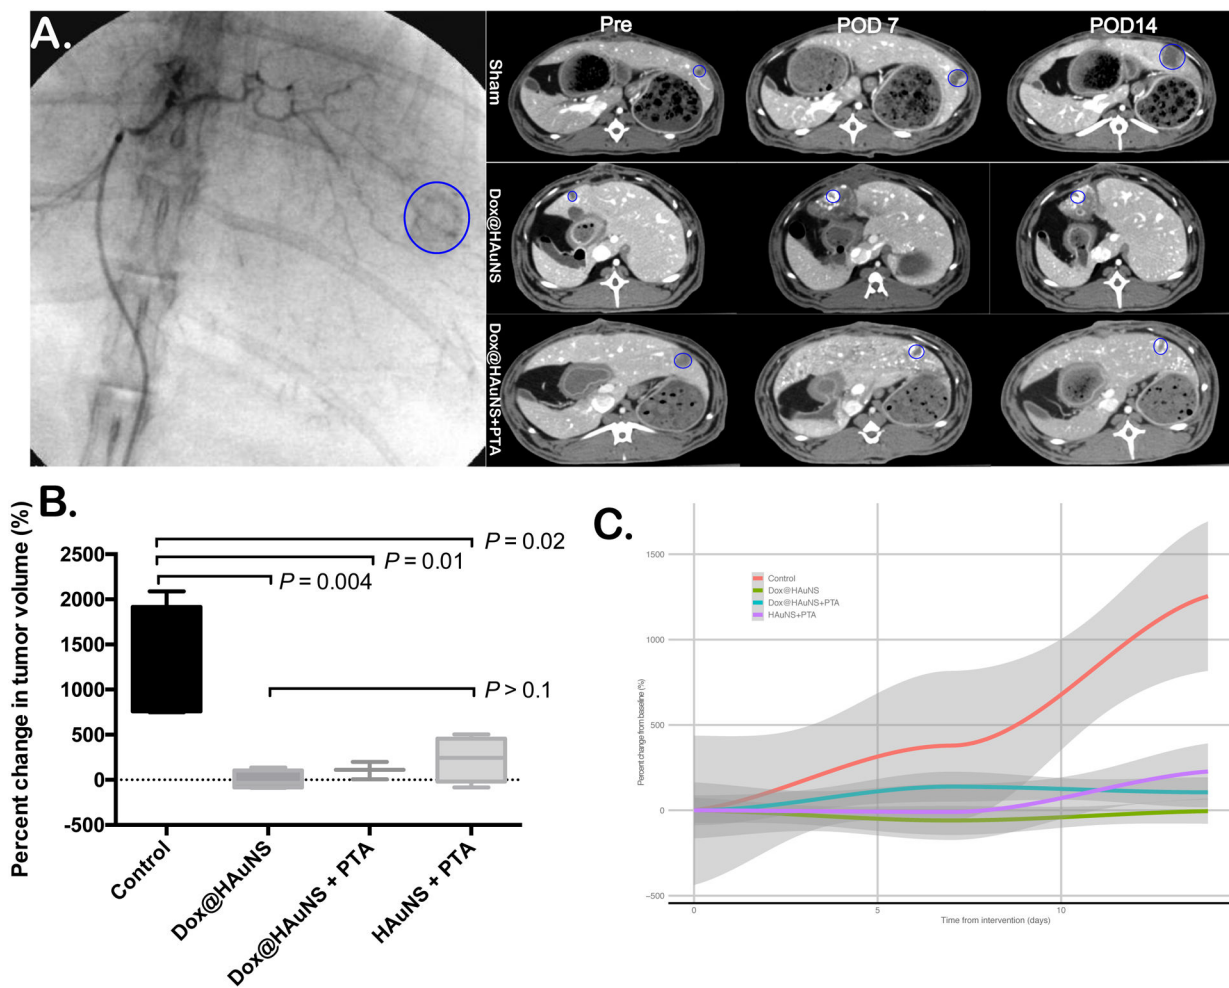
CT volumetric measurements.
